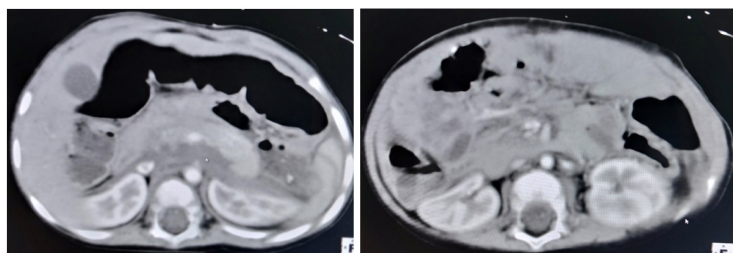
Abdominal CT in axial section after 3 months postoperative showing a normal aspect of the retroperitoneal compartment.
